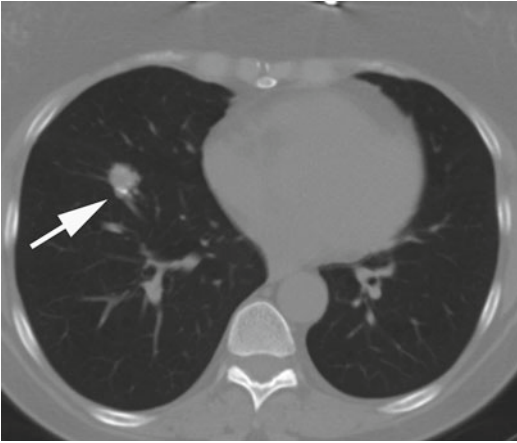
Eccentric calcifications within nodule. Axial CT reveals spiculated nodule with coarse peripheral calcifications (arrow). Initial FNA non-diagnostic. Wedge resection revealed amyloidoma
